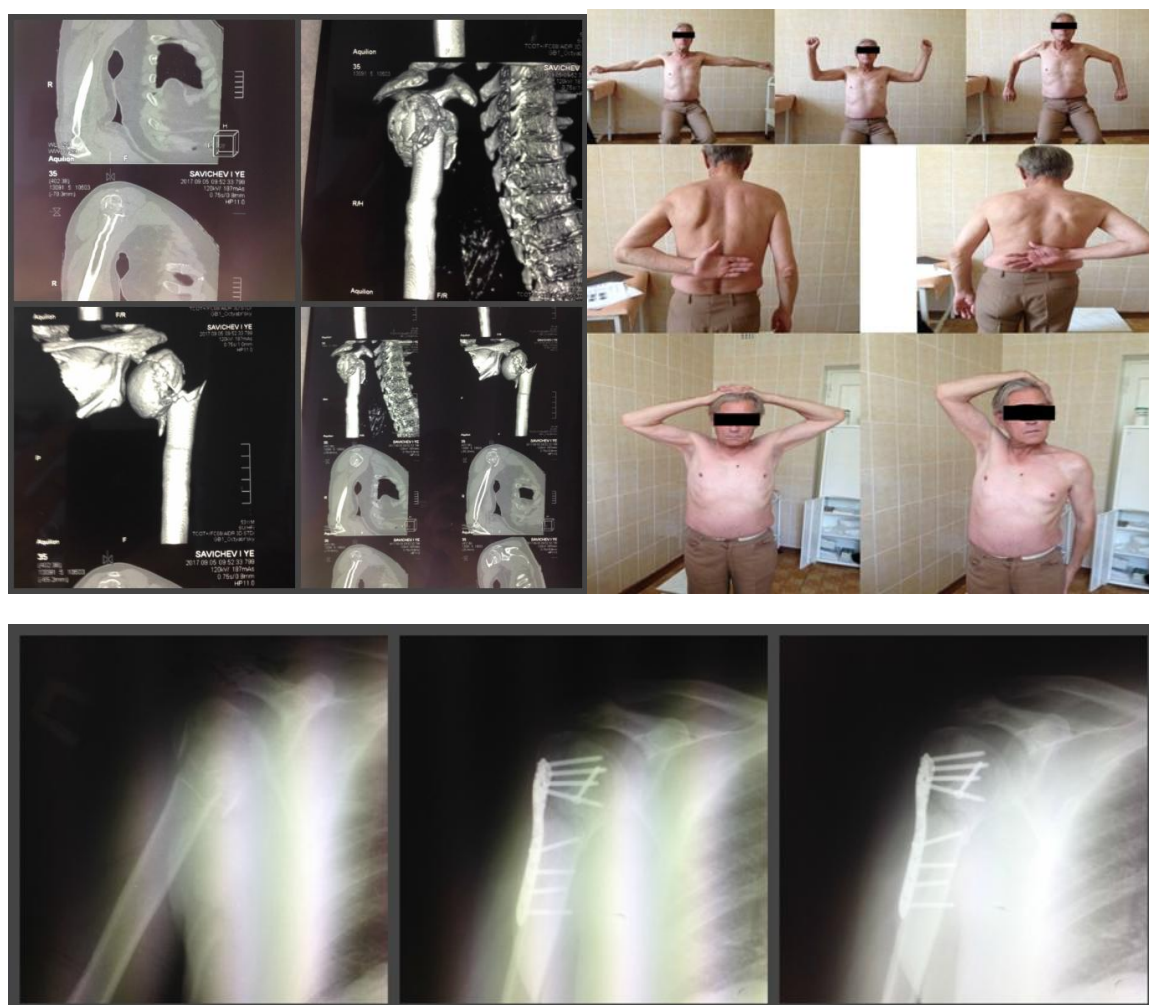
shows a clinical example of a 65-year-old patient with type 1.1.B.2 AO/ASIF damage. Through the anterior deltoid-pectoral access, open reposition was performed, bone osteosynthesis with a fixator with angular stability, then intraoperative revision of the rotator cuff components, the detachment of the supraspinatus muscle from the attachment site was revealed, and refixation was performed. On computed tomography, the multifragmental nature of the destruction and deficiency of bone tissue is determined. After surgery, antibacterial and analgesic treatment was performed. On the second day, an x-ray of the operated shoulder joint was performed. On the second day, finger movements, movements in the elbow, as well as in the wrist joint are allowed. Patients were given a retention splint.
